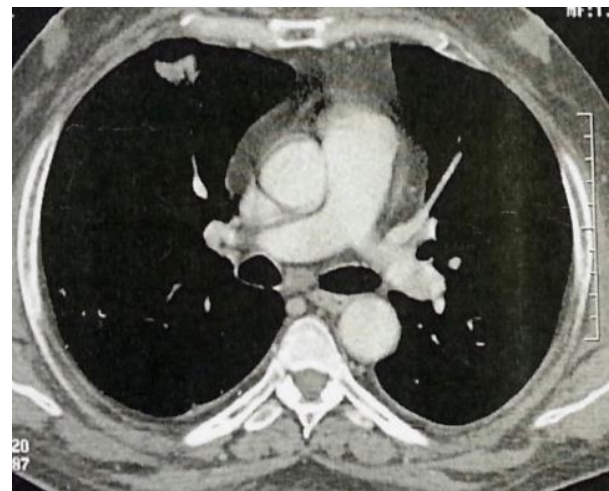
Thoracic CT scan : pulmonary nodule on the middle lobe.
